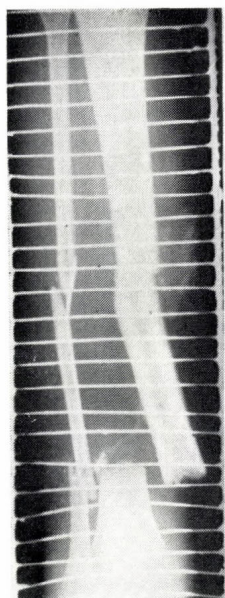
X-ray picture of an open, fragmentary shin-bone fracture
